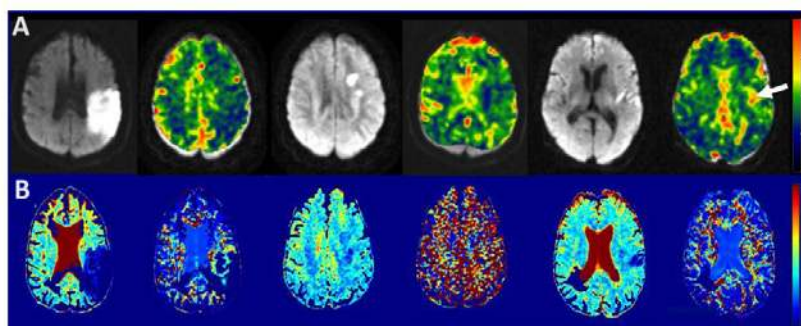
Example of DWI at b=1000 to identify the ischemic ROI and CVR maps, first participant (P25) has decreased CVR value and the third participant (P11) has increased CVR value. B. Maps of diffusion
